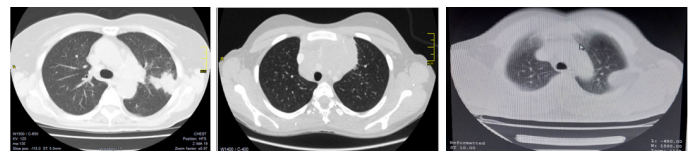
Chest CT images in soft tissue window. Image A. Prebiopsy of left pulmonary nodule. B. Prebiopsy of anterior superior mediastinal widening. C. Prebiopsy of left subpleural lesion.
